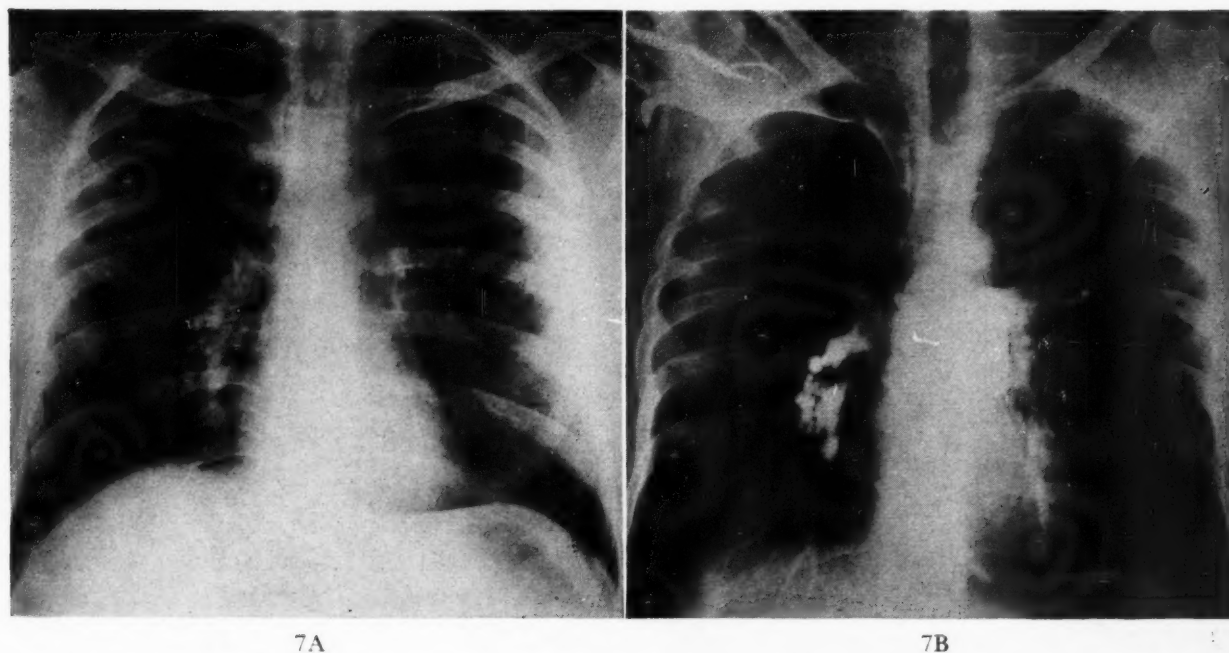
Case VII. Right middle lobe arteriovenous fistula in a patient with meningoencephalitis. A, conventional frontal roentgenogram shows increased vascularity of right hilar vessels. B, frontal angiogram shows arteriovenous fistulous malformation. Lateral view (not shown) showed fistula to be in middle lobe.
